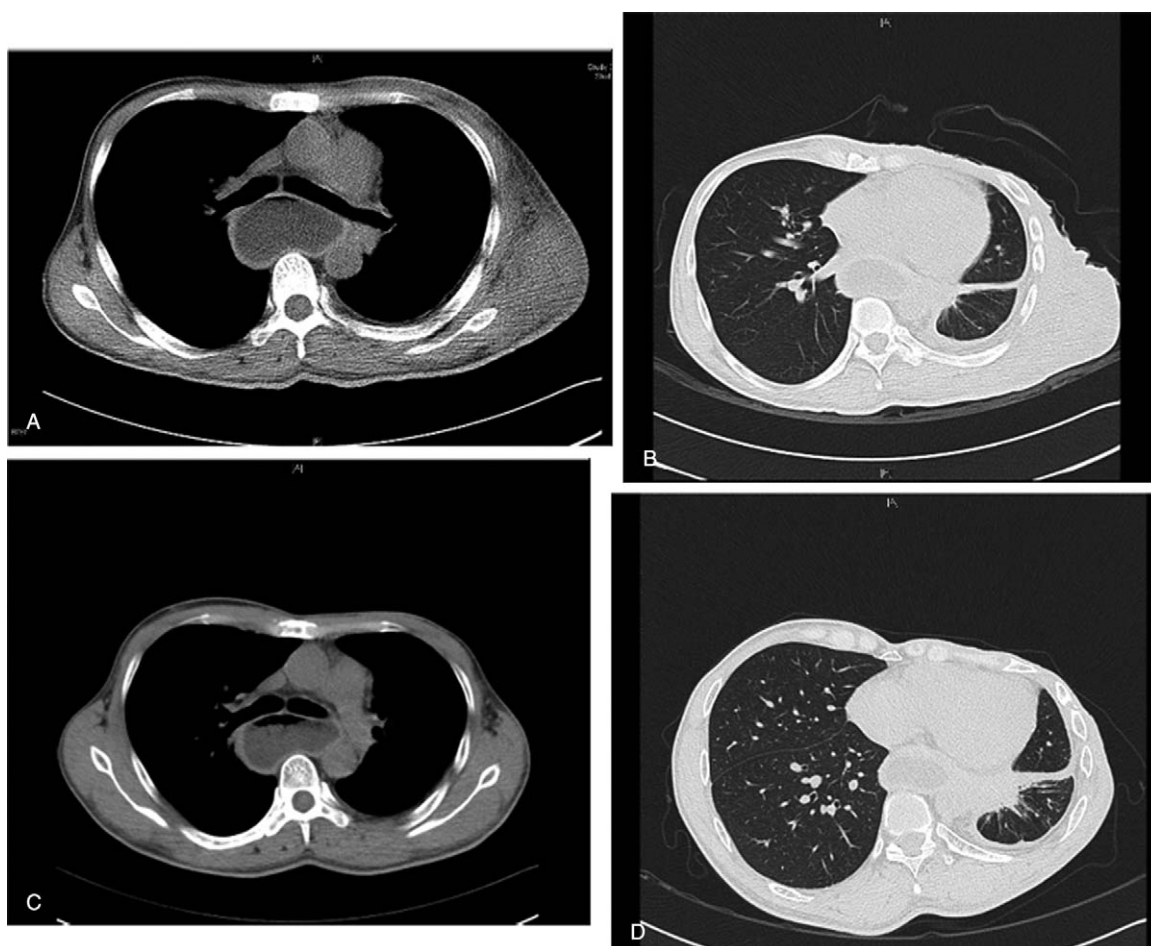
Chest CT scan before the treatment indicated swelling of the soft tissue of the left chest and abdominal wall (A for mediastinal window and B for pulmonary window). After 5-month treatment, the chest CT scan showed obvious diminution of the mass (C for mediastinal window and D for pulmonary window).
